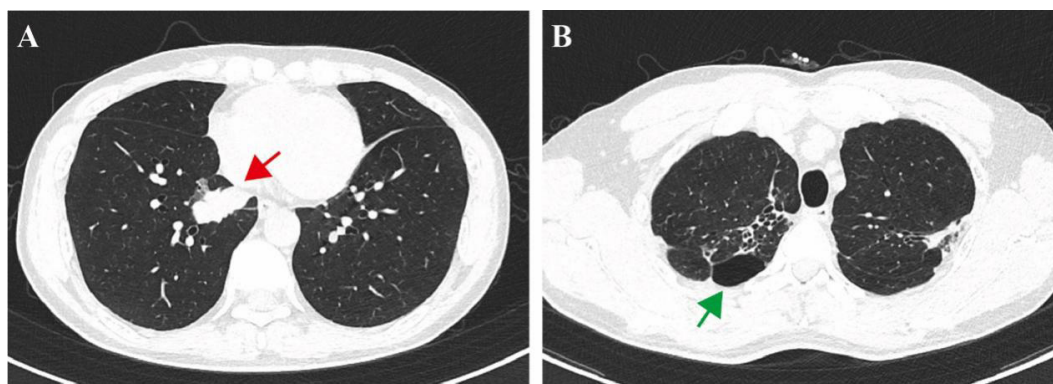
(A) Chest CT image demonstrating a high-density mass (red arrow) located in the basal segment of the right lower lung. (B) Chest CT reveals a lymph node shadow (green arrow) at the right lower pulmonary hilum.
